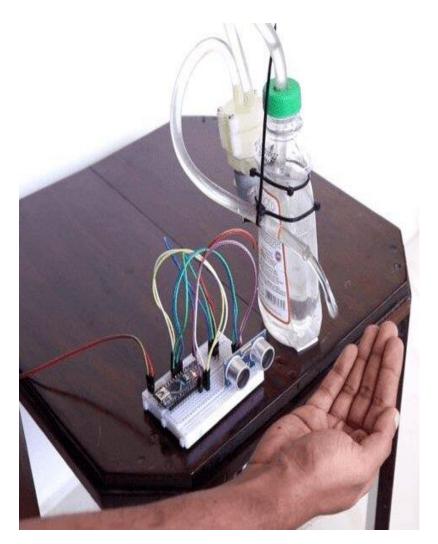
Ultrasonic sensor senses the distance of object
